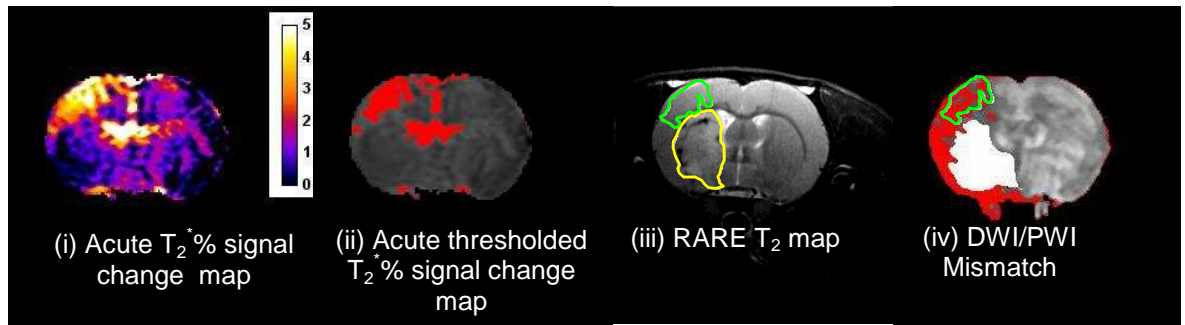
Comparison of neuroanatomical location of thresholded OC-defined penumbra in relation to T₂-defined final infarct and DWI/PWI mismatch. Acute T₂* percentage signal change map (i) was thresholded to identify penumbra (ii) and superimposed upon the day 7 RARE T₂ (iii)—penumbra outlined in green. The final infarct is outlined in yellow. The T₂*OC penumbra region of interest (ROI) was superimposed upon the DWI/PWI mismatch (iv) to compare the difference in the spatial locations of the mismatch and the T₂*OC defined penumbra
